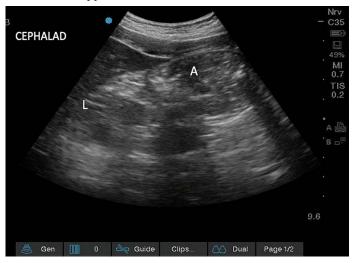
Solids in antrum on Gastric sonography, (L -Liver, A - Antrum)
